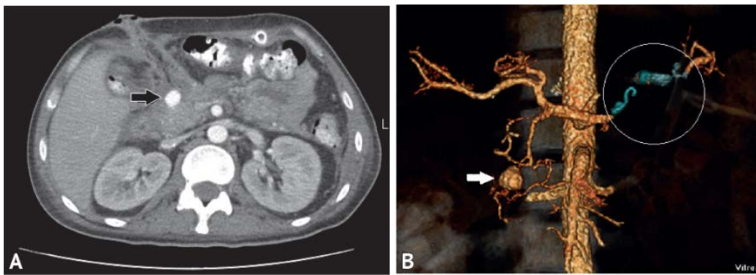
CT scan of the abdominal cavity with contrast enhancement: A — axial view; B - 3D reconstruction. Condition after filling the drainage canal. A spherical pseudoaneurysm of the gastroduodenal artery is determined in the area of the bottom of the drainage channel (arrows in Fig. 6A and 6B). Spiral emboli in the lumen of the splenic artery with reduced blood flow (highlighted in a circle in Fig. 6B)
